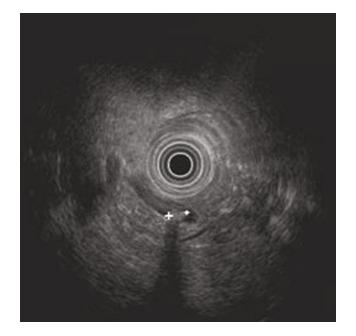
Endoscopic Ultrasonographic Image of Choledocholithiasis. Echo-rich areas with typical postacoustic shadowing are seen within the common bile duct.
